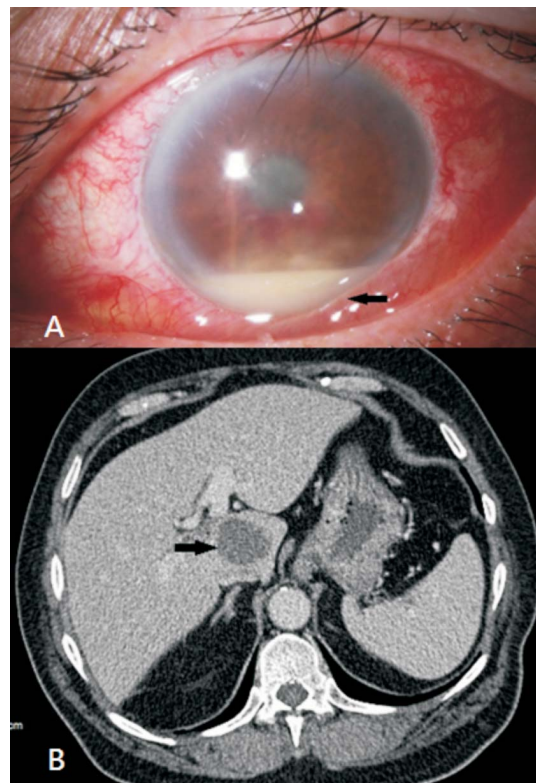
(A) Slit-lamp examination showing the presence of hypopyon, a collection of pus in the anterior chamber (arrow). (B) Abdominal CT showed a 3.5 × 2.8 cm, heterogeneous, low-density liver abscess in the S1 segment (arrow).
